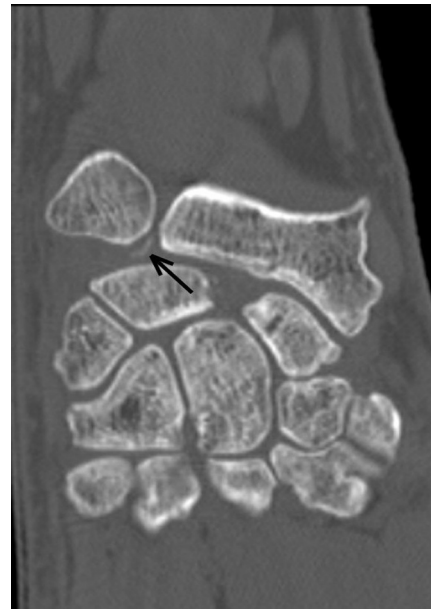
Coronal CT slice of the left wrist: pathological scapholunate diastasis, calcifications of the triangular fibrocartilage complex (arrow) and in the scapholunate space.
